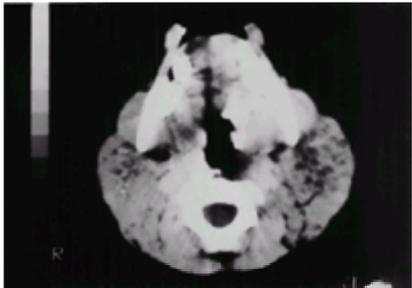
CT scan of parotid glands in an HIV-infected child with DILS, demonstrating bilateral glandular enlargement with cystic changes.
